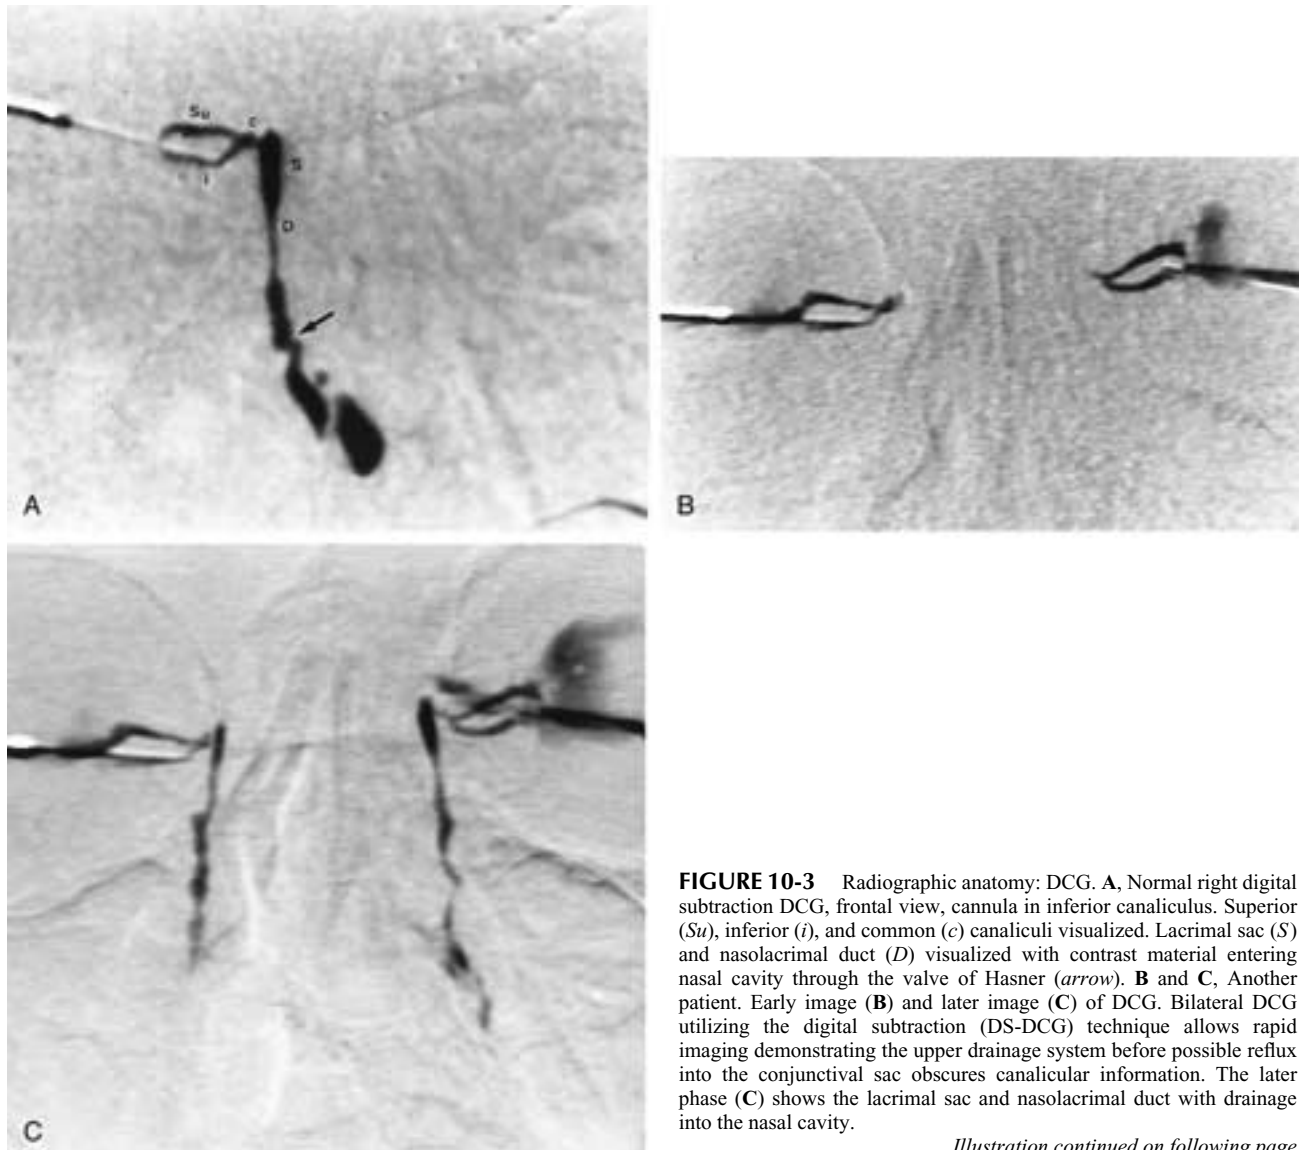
Radiographic anatomy: DCG. A, Normal right digital subtraction DCG, frontal view, cannula in inferior canaliculus. Superior (*Su*), inferior (*i*), and common (*c*) canaliculi visualized. Lacrimal sac (*S*) and nasolacrimal duct (*D*) visualized with contrast material entering nasal cavity through the valve of Hasner (*arrow*). B and C, Another patient. Early image (B) and later image (C) of DCG. Bilateral DCG utilizing the digital subtraction (DS-DCG) technique allows rapid imaging demonstrating the upper drainage system before possible reflux into the conjunctival sac obscures canalicular information. The later phase (C) shows the lacrimal sac and nasolacrimal duct with drainage into the nasal cavity.
